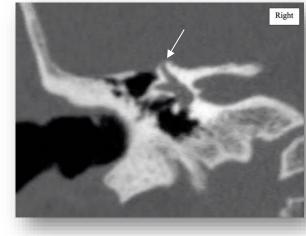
Coronal CT Scan of the temporal bone showing dehiscence of the right superior semicircular canal (patient 2)
